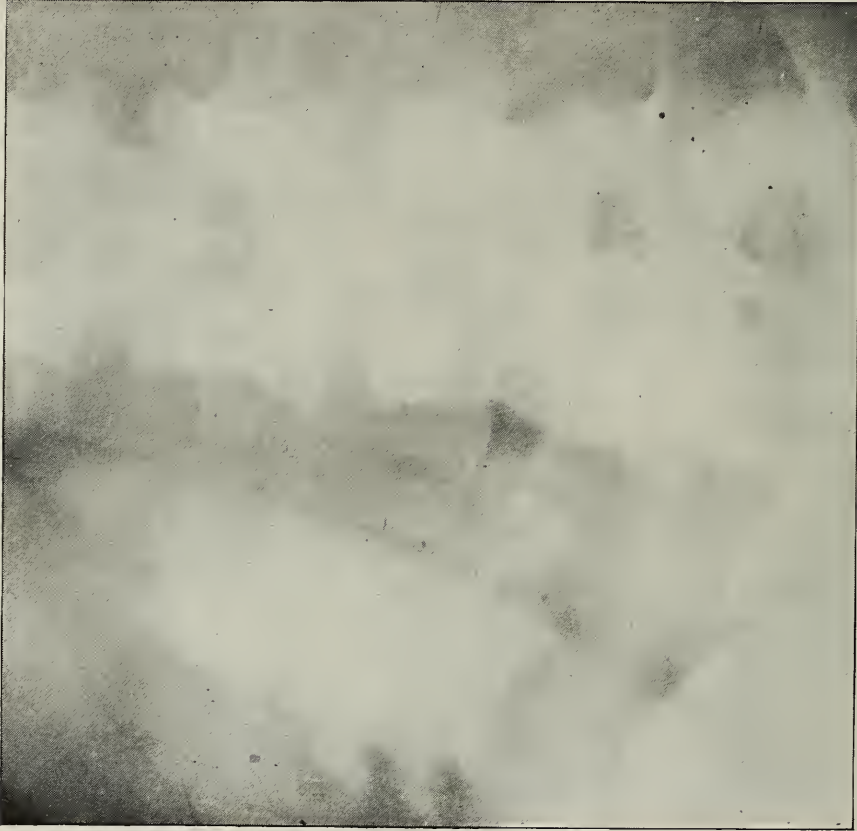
X-ray No. 12674. Region: right lumbar. Intermittent hydronephrosis. Varies in size from a few ounces to size of a child's head. Note position of low-lying renal pelvis and tortuous condition of the ureter. Calyces not distended. At operation contained only three ounces.
